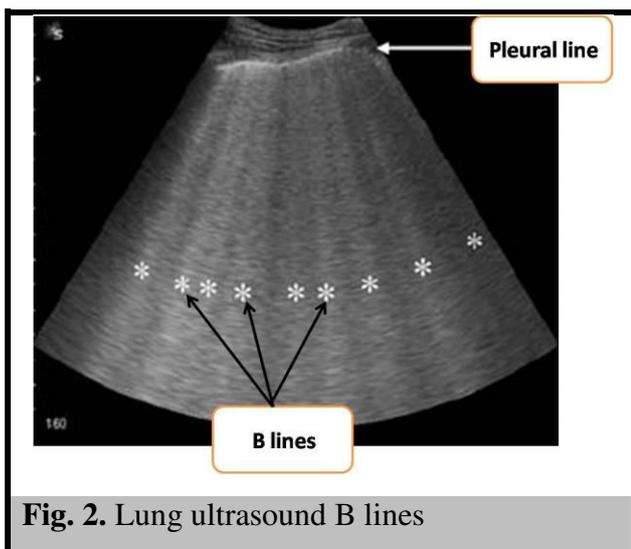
Lung ultrasound B lines
